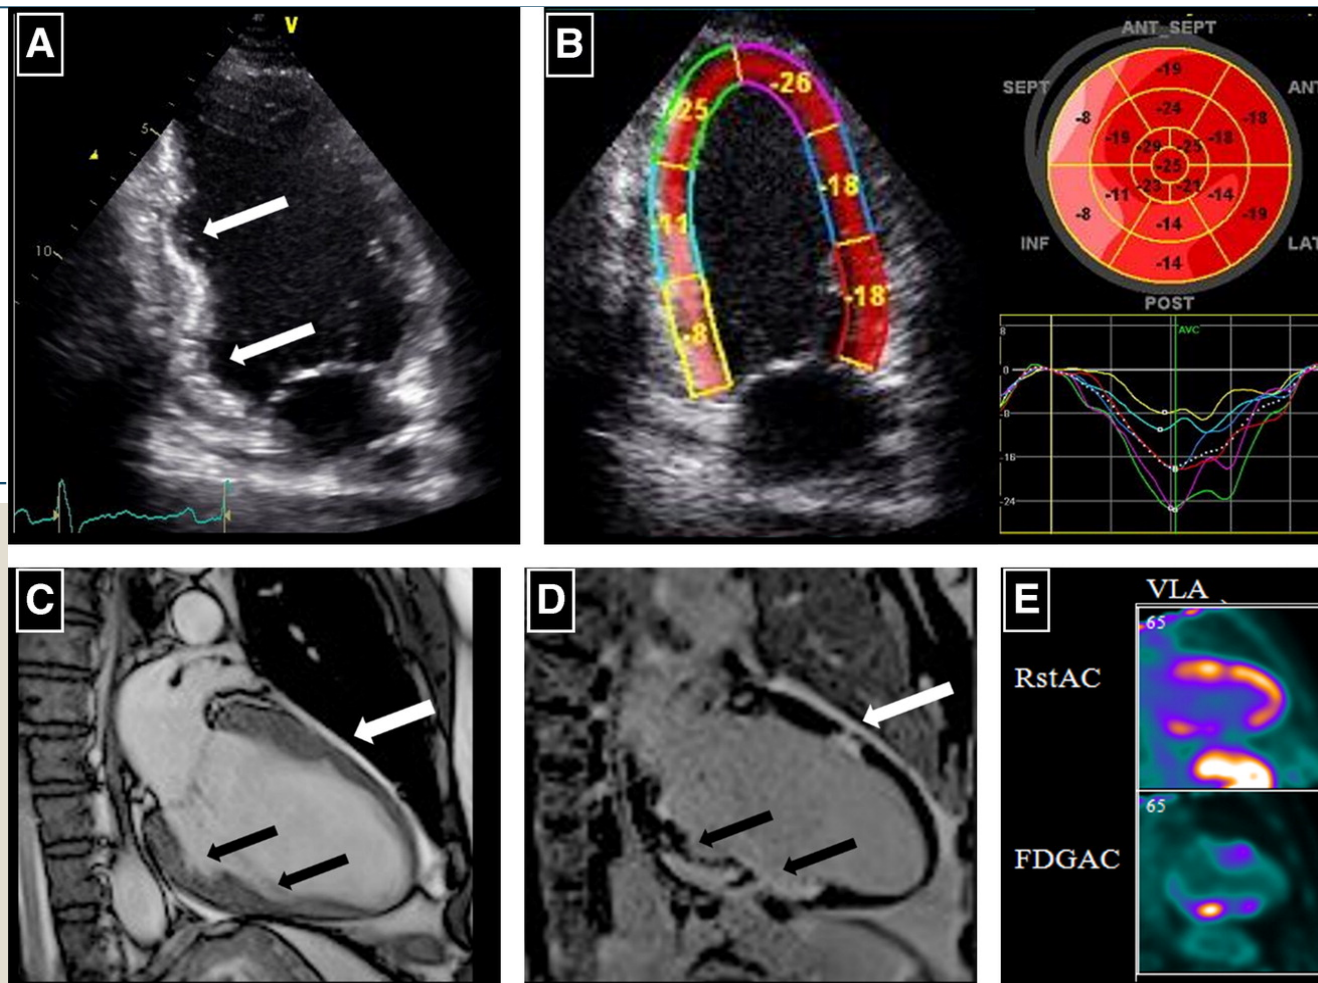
Multimodality cardiac imaging in a 49-year-old white man with cardiac sarcoidosis. (A) Transthoracic echocardiogram two-chamber view showing focal aneurysms in the basal and mid inferior wall (white arrows). (B) Two-dimensional longitudinal strain showing reduced regional strain in the basal to mid-inferior wall (yellow and aqua segments/lines on regional strain map [left] and graph [bottom right]), along with reduced strain (pink segments) in the basal to mid-inferior wall and basal infero-septum on global bull's-eye strain plot (top right). (C) Cardiac magnetic resonance imaging (MRI) vertical long axis (VLA) cine image showing inferior wall aneurysms (black arrows), as well as a small aneurysm in the mid anterior wall (white arrow), which was not detected by echocardiogram. (D) Corresponding cardiac MRI VLA phase-sensitive inversion recovery sequence showing near-transmural focal regions of delayed enhancement consistent with fibrosis or inflammation. (E) Cardiac positron emission tomography VLA demonstrating reduced resting perfusion in the mid-inferior wall (RstAC: top figure), along with increased fluorodeoxyglucose F 18 (FDG) uptake in the basal to mid-inferior wall and mid-anterior wall (FDGAC: bottom figure) supportive of active inflammation in these segments.
